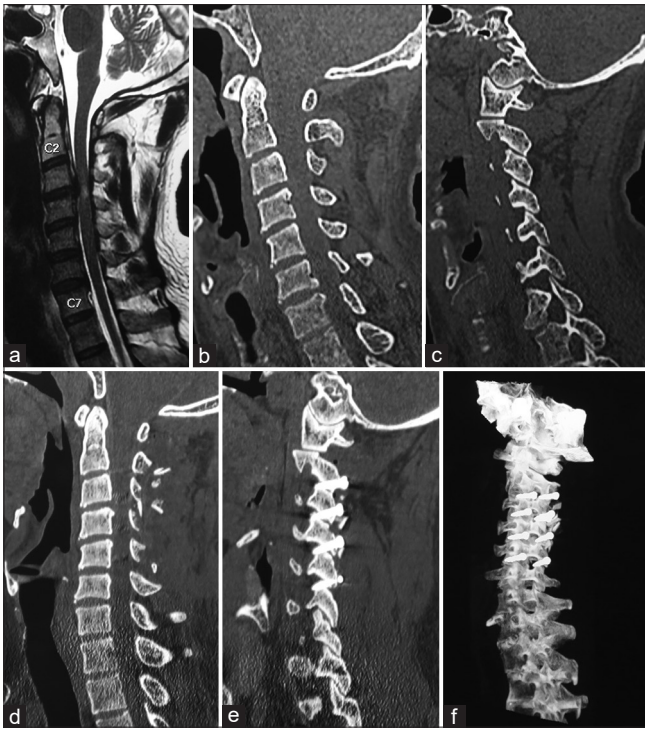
Images of a 46-year-old male patient [Table 1- Case 5]. (a) T2-weighted magnetic resonance imaging showing degenerative spinal changes at C3-4 spinal segment. Intrinsic cord changes are seen opposite the disc bulge at this level. (b) Sagittal image of computed tomography scan showing no evidence of bone injury or instability. (c) Sagittal image of computed tomography scan with the cut passing through the facets. No significant facetal instability is observed. (d) Postoperative computed tomography scan. There is no posterior decompression. (e) Postoperative computed tomography scan showing transarticular fixation at 4 spinal segments. (f) Computed tomography scan showing the screws
